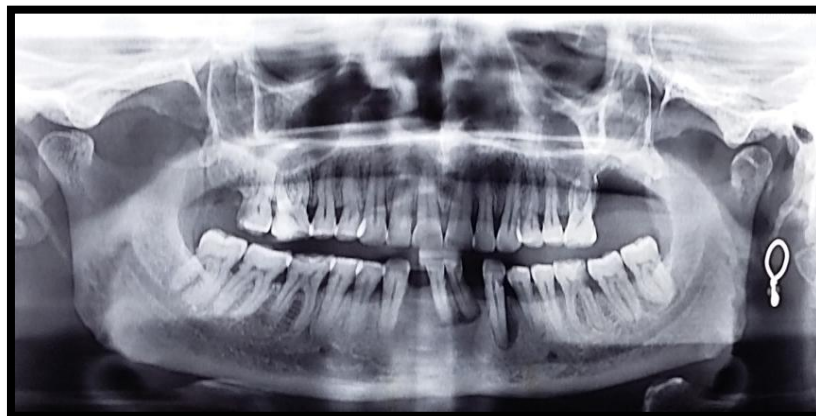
Panoramic X-ray showing bone defect with bone loss in relation to upper first molar adjacent to OAF.
